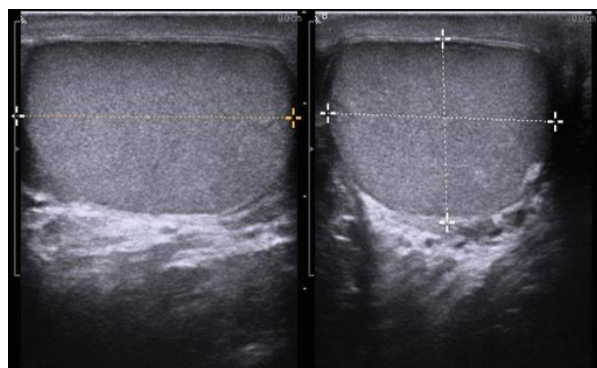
Ultrasound measurement of testicular volume.
